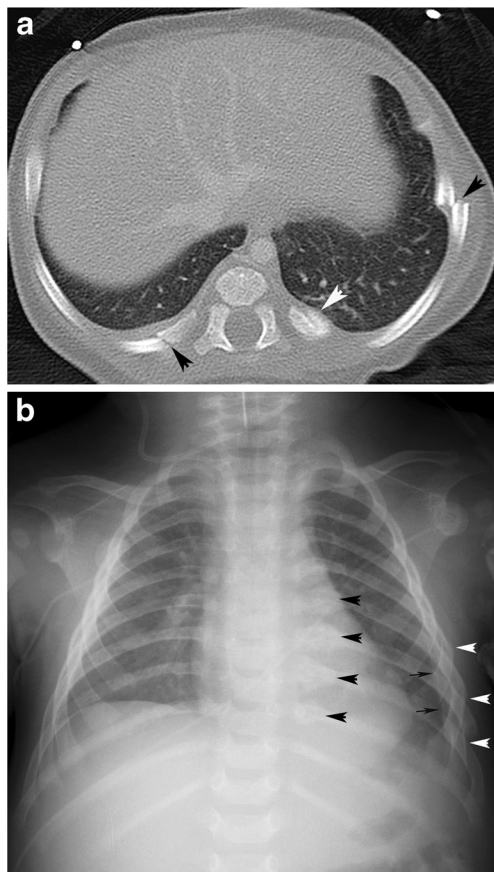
Imaging in a 6-week-old boy who had become limp and unresponsive found cranial and bilateral posterior thoracic bruising, subdural hemorrhage with decreased gray–white matter distinction, multilayer profuse retinal hemorrhages with bilateral schisis cavities and a healing impacted distal radius fracture. He had a history of scleral hemorrhage and brow bruising. a Axial chest CT image on the day of admission shows that left lateral and right posteromedial rib fractures (*black arrowheads*) are acute while left posteromedial rib fracture has soft callus (*white arrowhead*). There is no evidence of pulmonary contusion or other intrathoracic injury except for minimal pleural thickening. b Anteroposterior chest radiograph 2 days later shows subacute posteromedial rib fractures with soft callus (*black arrowheads*). There are acute right-side rib fractures (*white arrowheads*) of differing ages with subadjacent pleural thickening or fluid (*small black arrows*). Multiple ages of rib injury and superficial intrathoracic injury are associated with abuse
